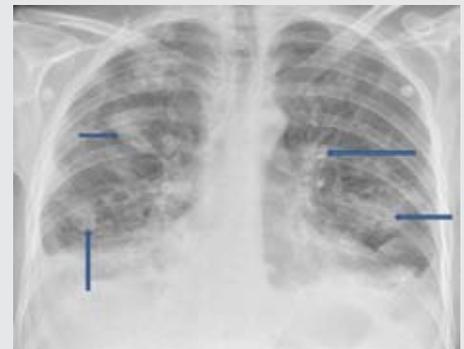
Plain chest radiograph showing multiple irregularly defined patches of consolidation (arrows) distributed throughout both lung fields, with loss of the cardiac silhouette at both the right and left heart borders, as well as bilateral blunting of both costophrenic angles to the lower zones
